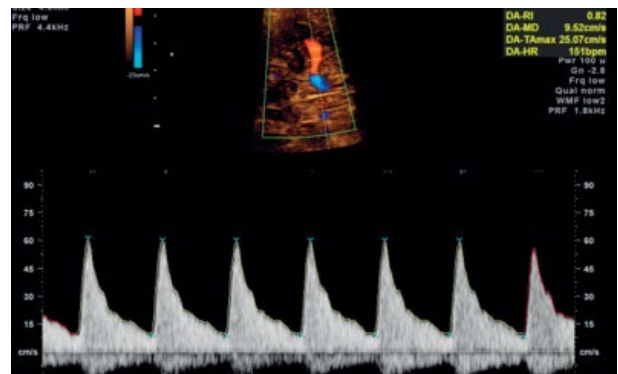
Acceptable middle cerebral artery Doppler shift waveform. Note insonation angle near 0°.
